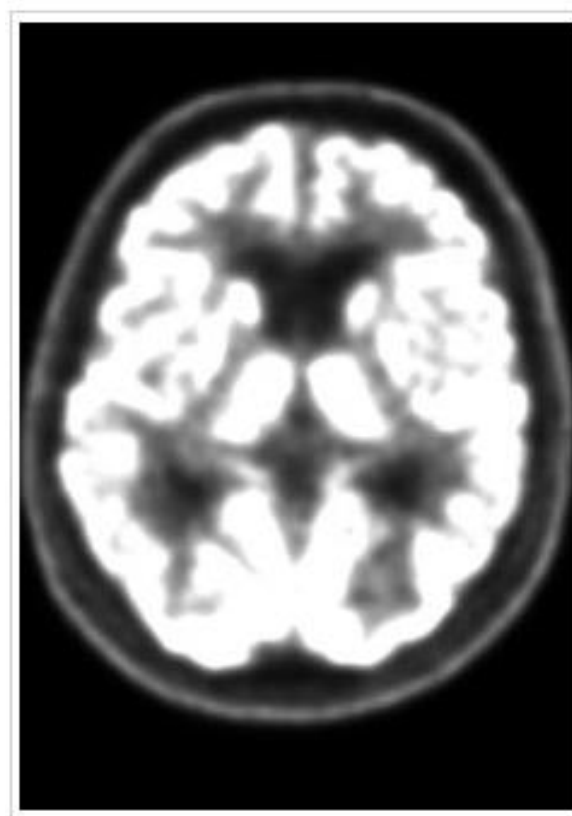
b. FDG PET TAC negative in first patient.
